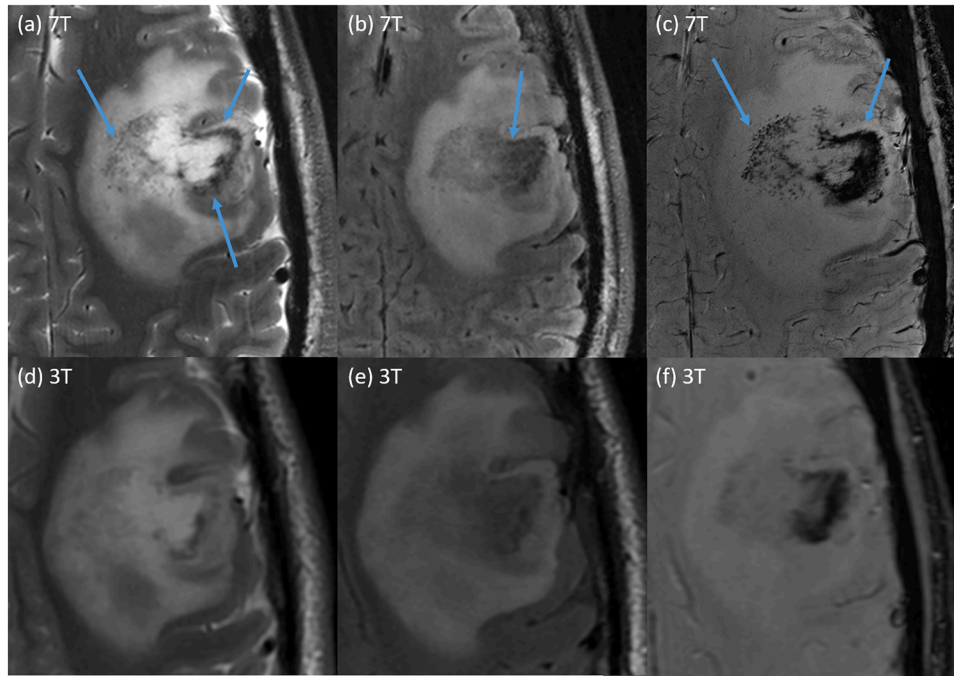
Structural imaging of a patient with a left frontal brain tumour (oligodendroglioma) including (a) a 7T T₂-weighted TSE, (b) T₂-FLAIR, and (c) SWI and corresponding 3T (d) T₂-weighted TSE, (e) T₂-FLAIR, and (f) SWI. The 7T imaging is of higher resolution, SNR and CNR, demonstrating the tumour matrix exquisitely (arrows). The 7T imaging allows for high resolution showing tumour heterogeneity, calcification and blood products (arrows).
